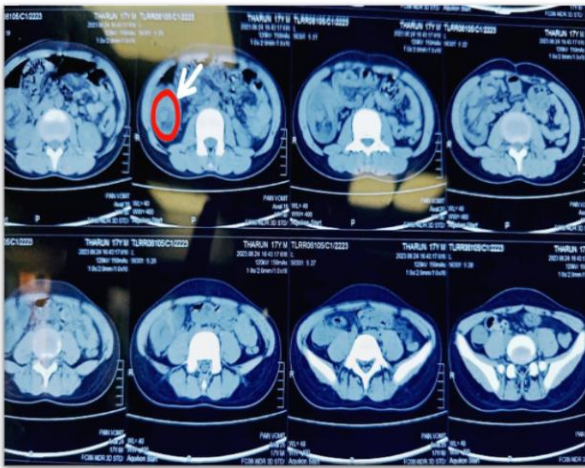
CT image of bowel within a bowel appearance.
